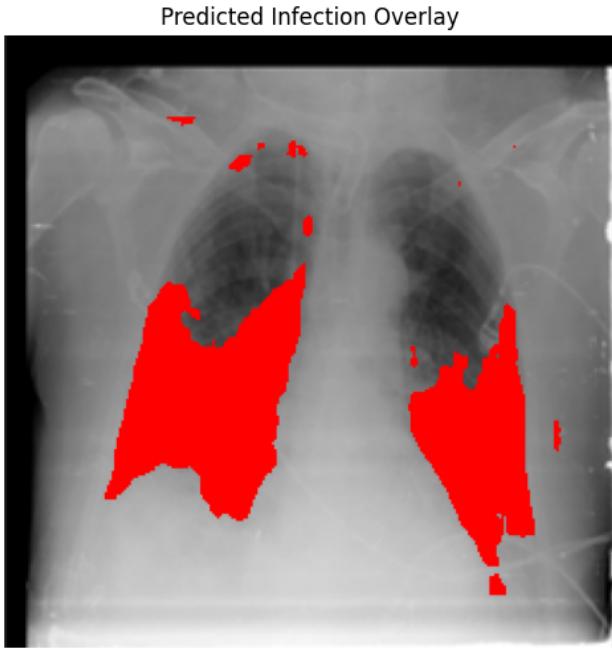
Predicted infection overlay on the input X-ray (highlighted region indicates predicted infected pixels).
